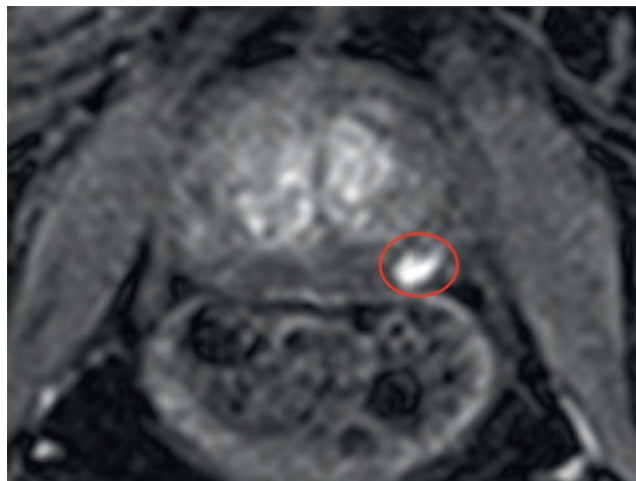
The same man from Figure 117-30 had this lesion confirmed on diffusion and dynamic-contrast magnetic resonance imaging. Here the early-phase contrast image is shown. This area underwent targeted template transperineal biopsies, and one biopsy showed Gleason 3+4 4 mm.
